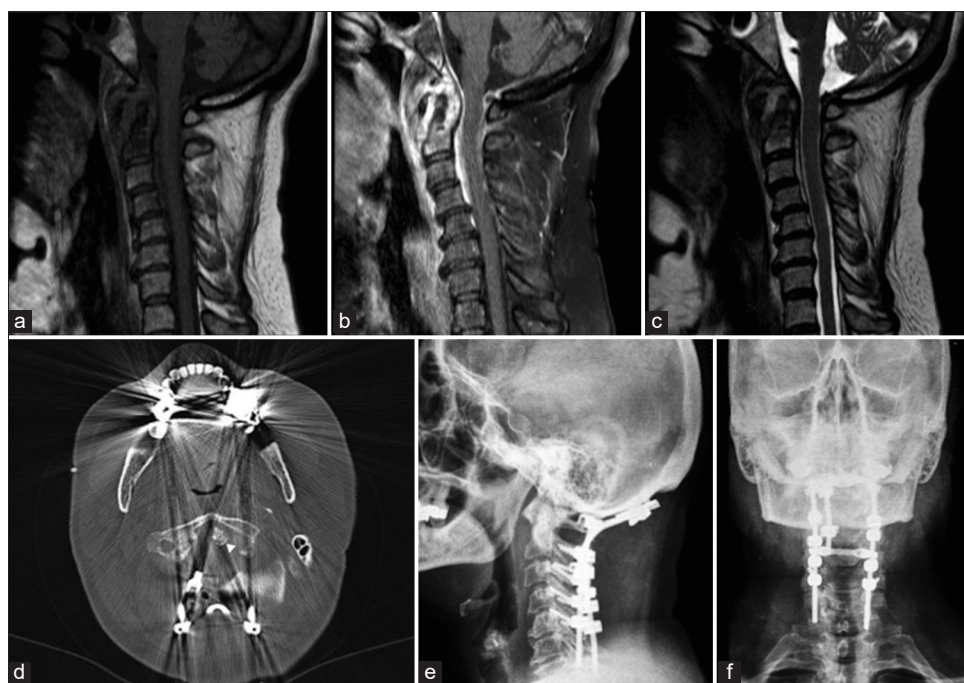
Sagittal sections from preoperative magnetic resonance imaging (a-c) indicating tissue formations that suggest an expansive process at the atlantodental joint, with low signal at T1 (a), intense enhancement after contrast injection (b) and heterogeneous signal at T2 (c). In (d), it is presented an axial section of a computed tomography image of the cervical spine obtained at the immediate postoperative period of occipitocervical arthrodesis; the arrow points to the calcification halo around the axon odontoid process. In (e) and (f), it is presented the final result of the occipitocervical arthrodesis.
